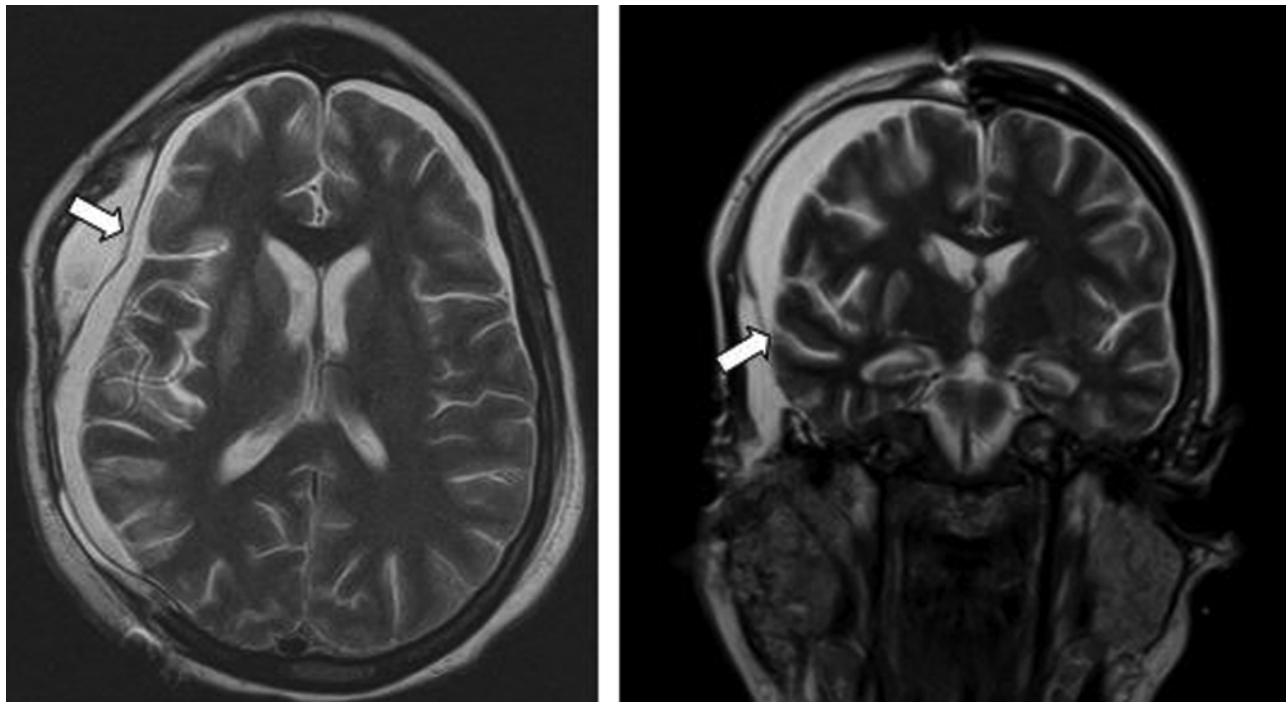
This 19-year-old woman underwent DC 5 days after her admission for ICP control and CPP management. Axial (*left*) and coronal (*right*) T2-weighted MR images obtained 14 days after a traumatic brain injury, indicating an SDG collection over and under the expansive duraplasty (*arrows*).
